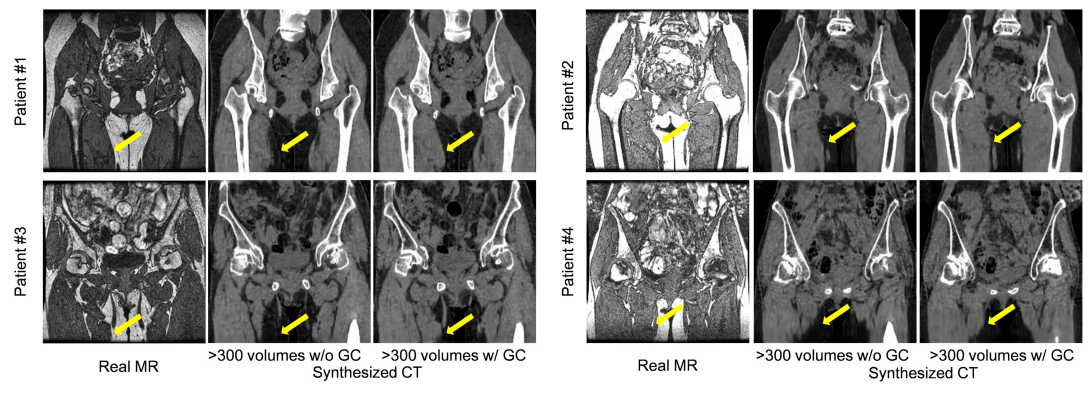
Representative results of translation from real MR to synthesized CT of four patients with and without the gradient consistency loss. As indicated by arrows, synthesized volumes with gradient consistency loss helped to preserve the shape near the adductor muscles.
